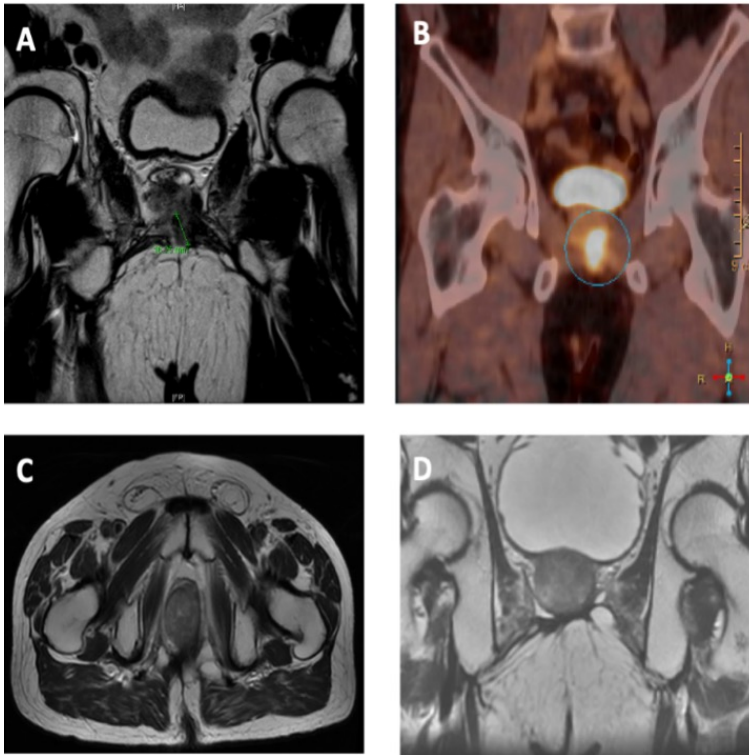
A. T2-weighted MRI showing a nodule in contiguity to the prostate gland, hypointense, 16 mm, suspected of malignancy without being able to define if is a primary tumor of the prostate gland or a metastatic lesion of another primary tumor. B. PET-CT showed a pathological increased metabolic activity at prostatic gland that suggest a malignant etiology. C and D. T2-wighted MRI shows complete remission at prostate gland.
